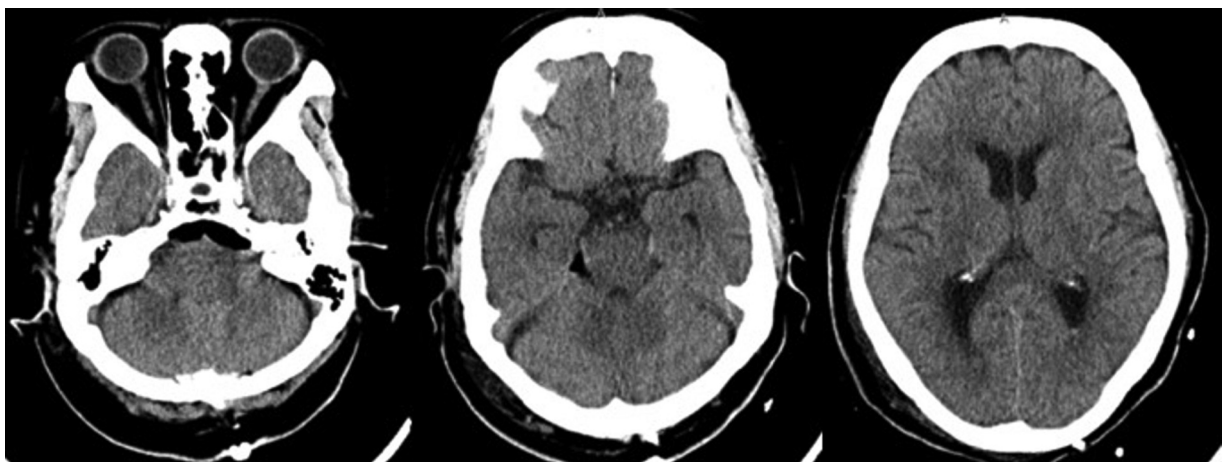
Computed tomogram images taken on the 1st day after surgery showing there were no cerebellar hemorrhage or hydrocephalus.
